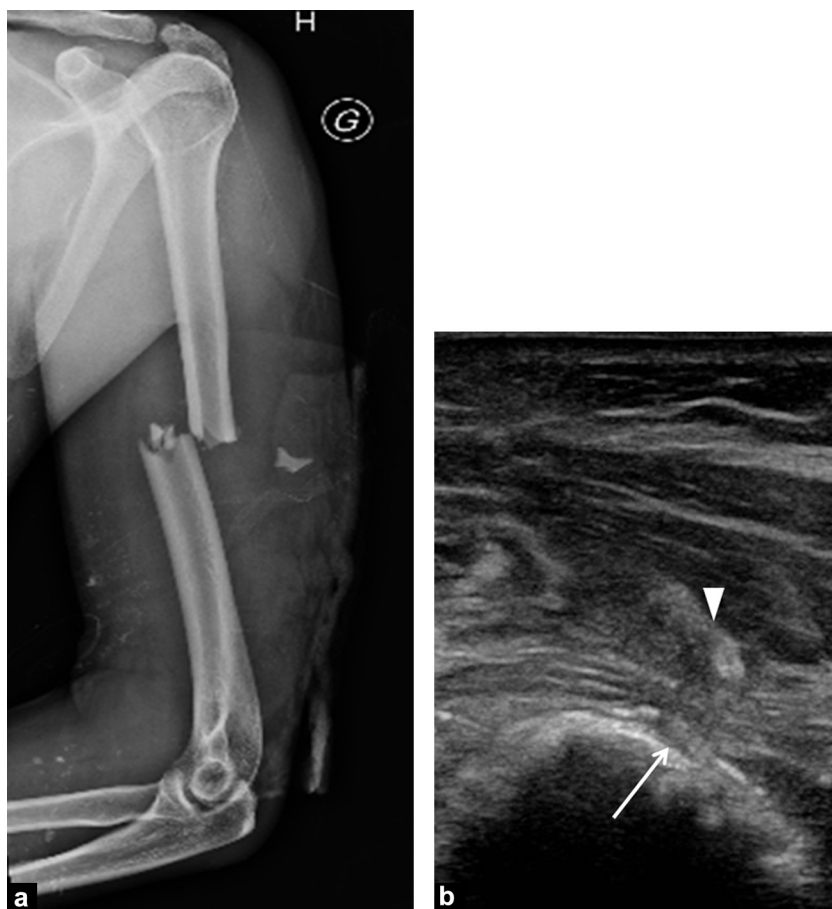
Paralysis of the left hand and wrist extensors 10 days after an open fracture treated by anterograde pinning in a patient with multiple trauma. a: radiograph of the displaced diaphyseal left humeral fracture; b: ultrasound image in the axial plane shows radial nerve damage (white arrow), grade 4 of the Sunderland classification: focal narrowing of the nerve with interruption of the epineurion and loss of fasciculated appearances reflecting damage to the perineuron combined with interruption of the brachial triceps (arrowhead) which suggests it passes through the bone, with damage to the muscle.
